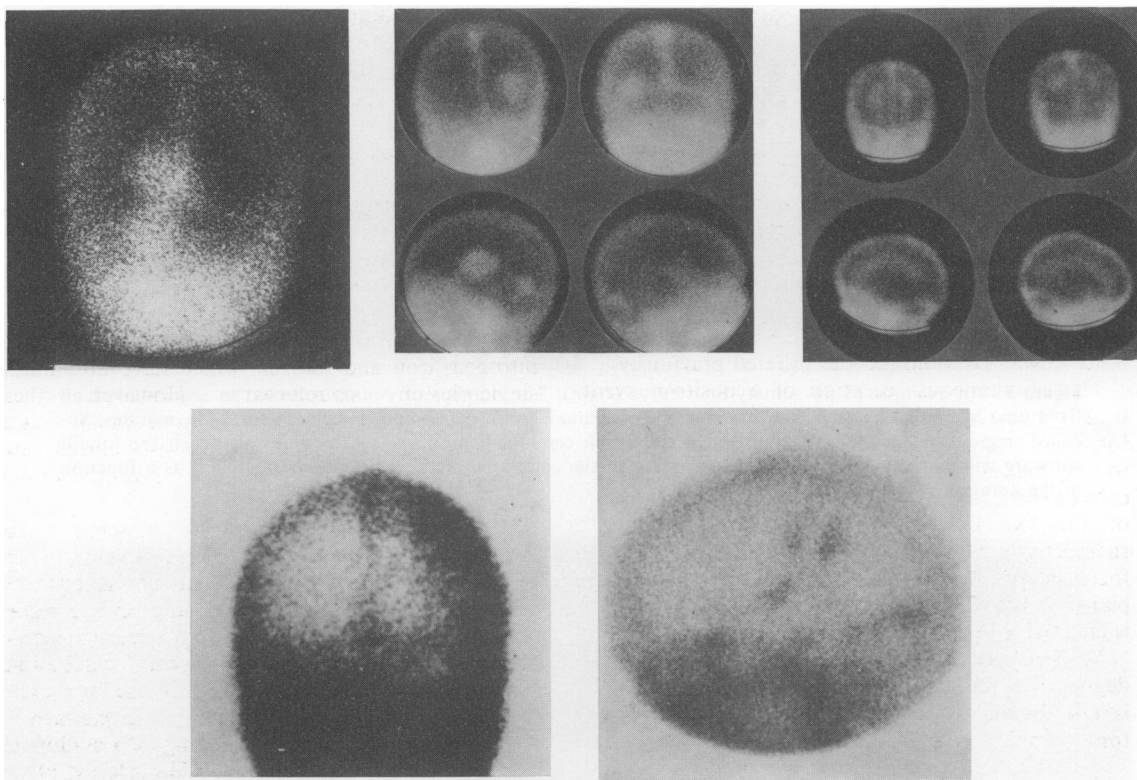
Examples of technetium-99m pertechnetate scintigrams showing a variety of cerebral lesions, where the radionuclide has penetrated the 'blood-brain barrier' into the lesion, depicting the latter as a photon-abundant area. Top left: falx meningioma; top middle: cerebral metastases from carcinoma of bronchus; top right: tuberculous ventriculitis; bottom left: subdural haematoma; bottom right; middle cerebral artery infarction.
